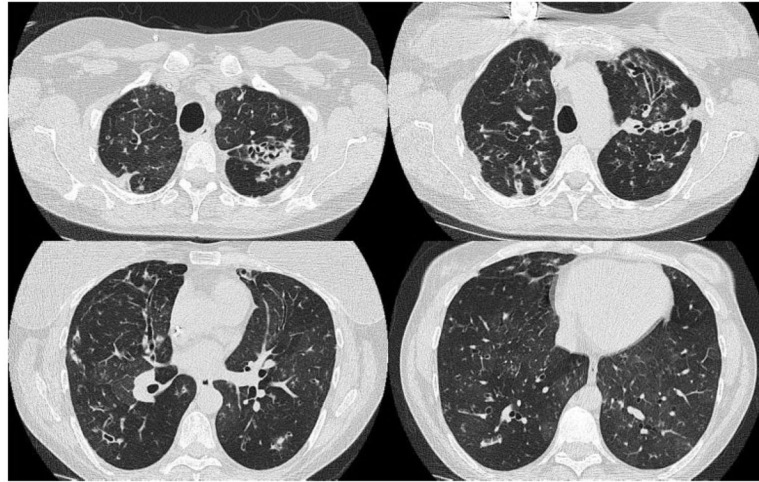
Chest CT of a 44-year-old woman with cystic fibrosis with severe lung disease and chronic *Pseudomonas aeruginosa* infection. The classic findings of bronchiectasis, mucus impaction, and air trapping are present. She later underwent successful lung transplantation.
